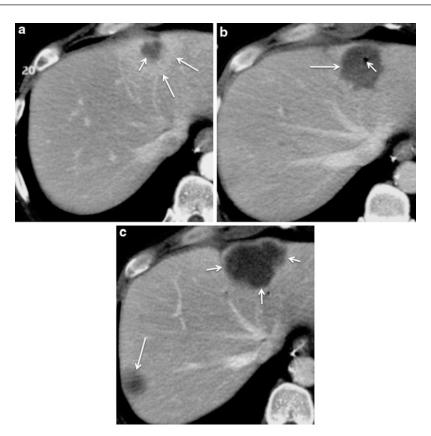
(a) Pretreatment CT from a patient with pancreatic carcinoma and a hypovascular left lobe liver metastasis (*short arrow*). This lesion is subcapsular and requires an indirect approach through normal parenchyma for safe ablation. The hazy enhancement surrounding the low-attenuation center (*long arrows*) suggests that the margins of the metastasis are larger than the hypovascular lesion alone. (b) Twenty four-hour post ablation CT demonstrating a sharply marginated hypovascular ablation
